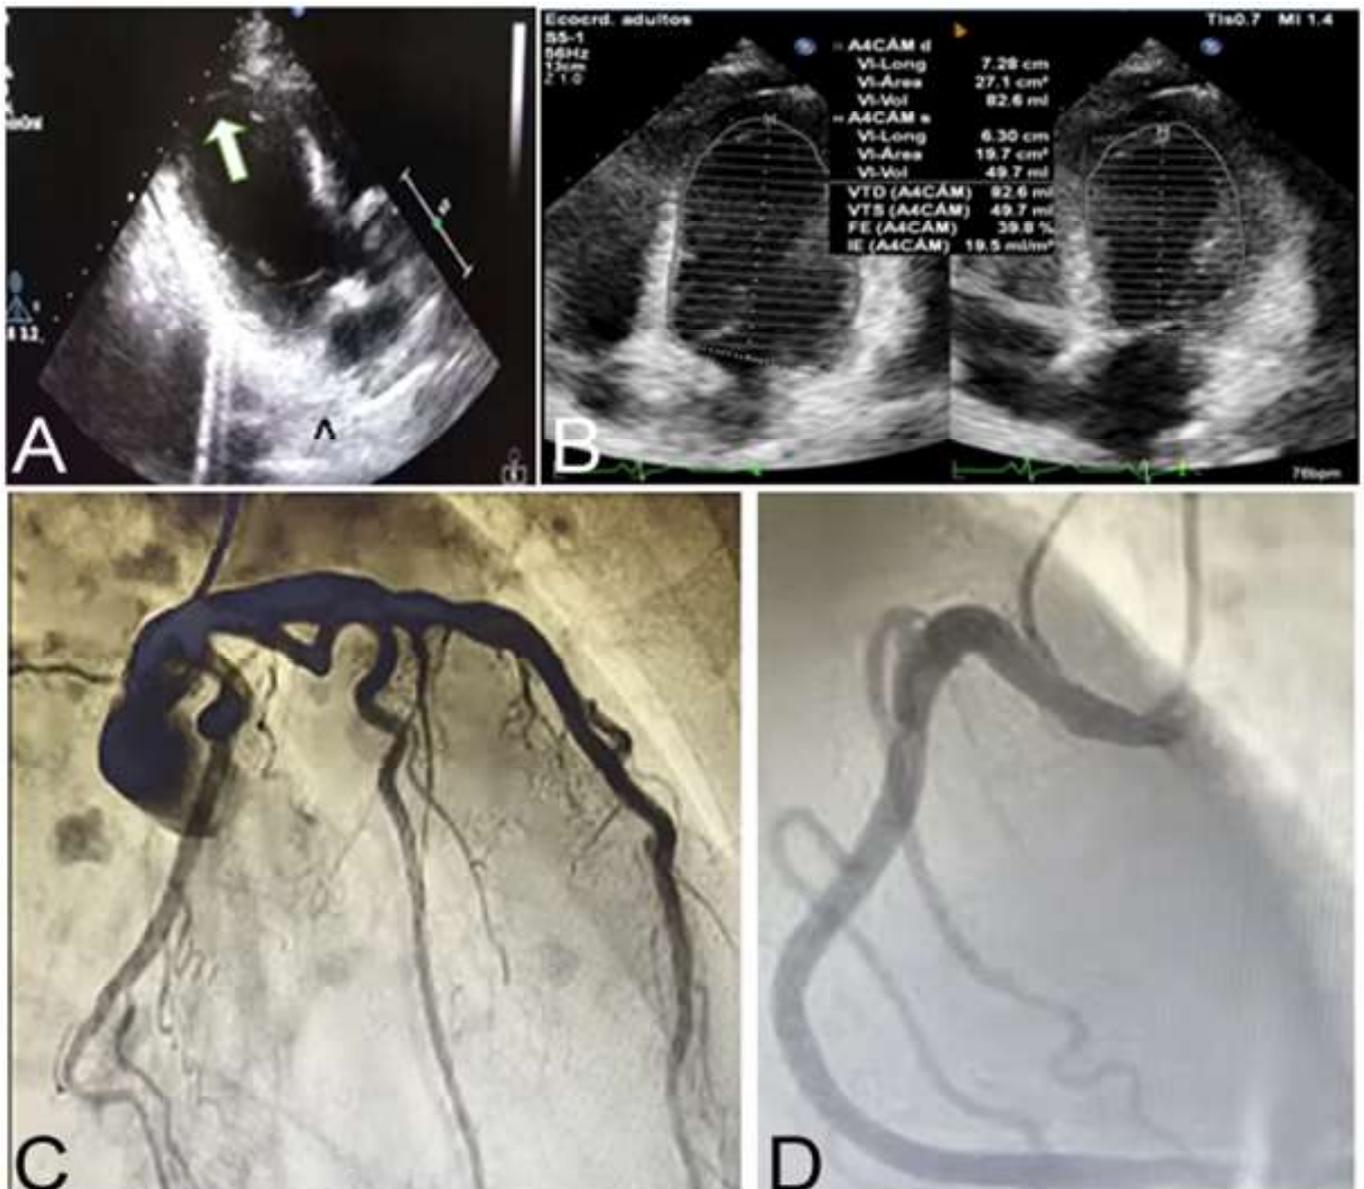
A. Two-dimensional echocardiogram. Apex hypokinesia, inferolateral apical (arrow) and septo-apical. B. Left ventricular ejection fraction 39.8%. C. Diagnostic coronary angiography. The trunk of the left coronary artery and the entire left system are observed without significant lesions, D. Right coronary artery without significant lesions.
